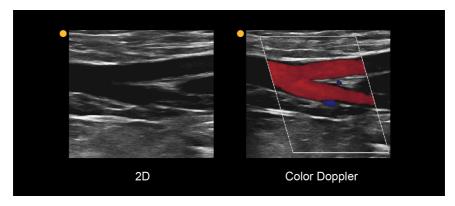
Three reasons for ordering arterial duplex ultrasound testing include an abnormal ankle-brachial index (ABI), suspicion of an aneurysm, and suspicion of a pseudoaneurysm.
